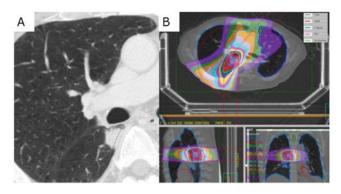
(A) A CT image before SBRT and (B) The irradiation field of a patient with grade 5 hemoptysis. He had massive hemoptysis ten months after SBRT and died. CT, computed tomography; SBRT, stereotactic body radiotherapy.
